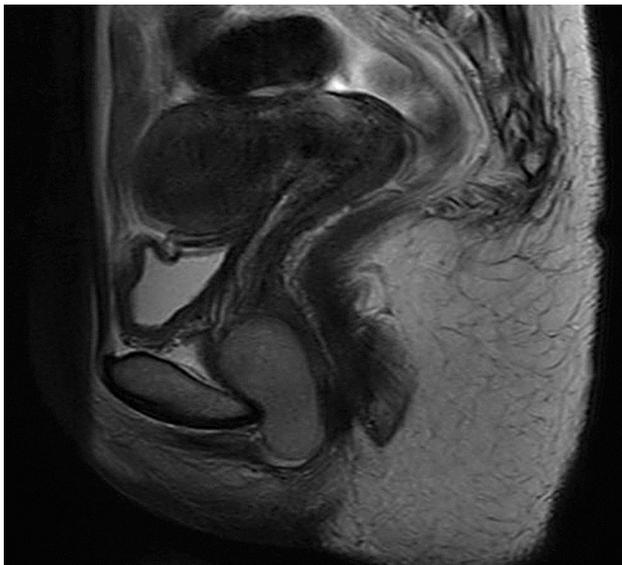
MRI examination of the pelvis which demonstrates a highly vascular mass of left vulva. There is no evidence of tumor invasion to the surrounding tissue.
